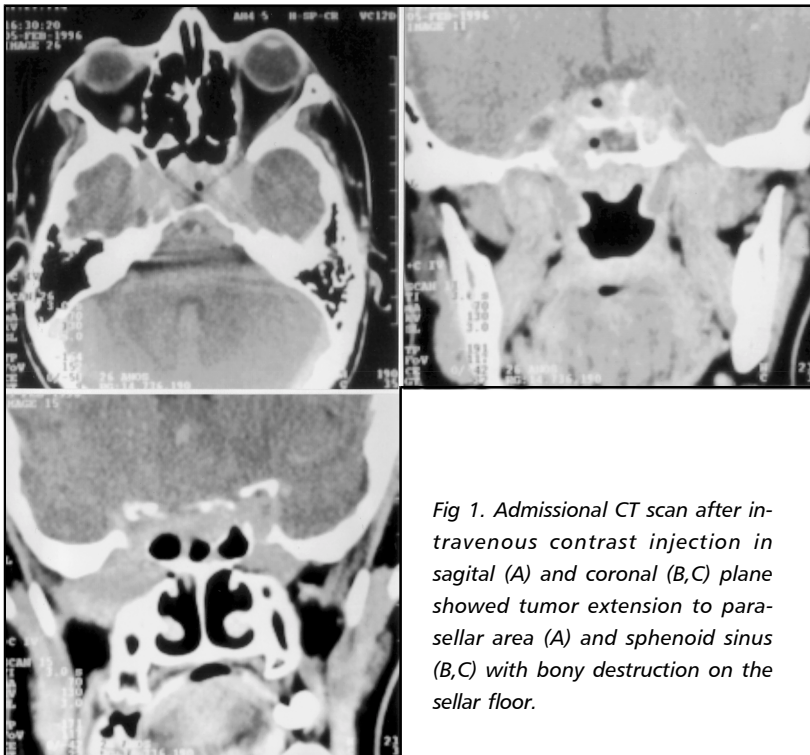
Admissional CT scan after intravenous contrast injection in sagittal (A) and coronal (B,C) plane showed tumor extension to parasellar area (A) and sphenoid sinus (B,C) with bony destruction on the sellar floor.
